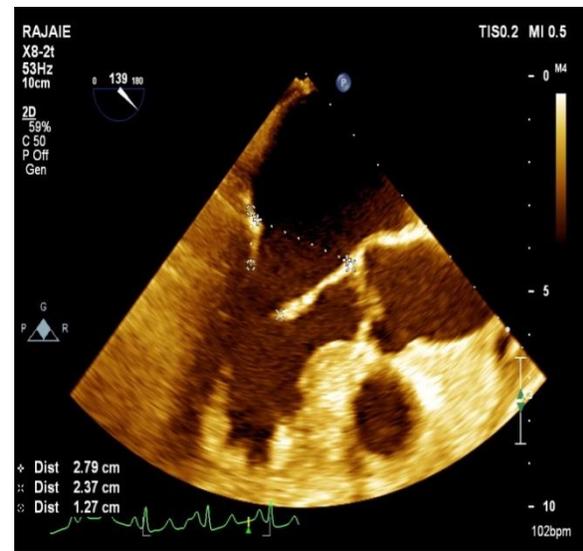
Transesophageal echocardiography view of the mitral and aortic valve is presented herein.
